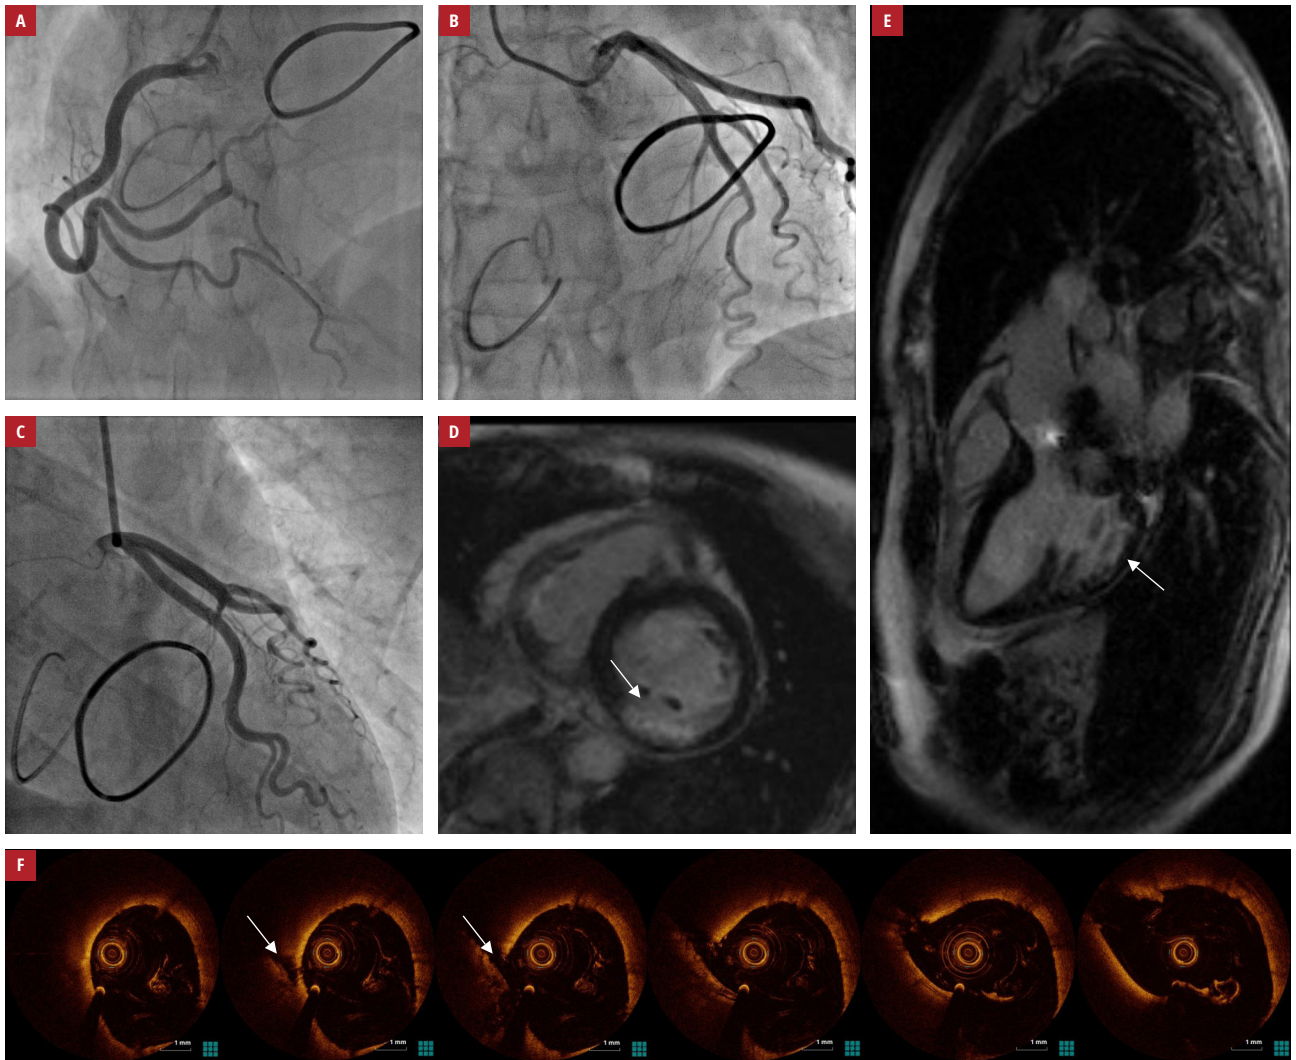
Imaging of a patient after cardiac arrest: A–C – coronary angiography showing coronary arteries with no significant lesions; D, E – cardiac magnetic resonance imaging demonstrating the subendocardial scar in the left ventricle (arrows); F – optical coherence tomography showing plaque rupture (arrows)
